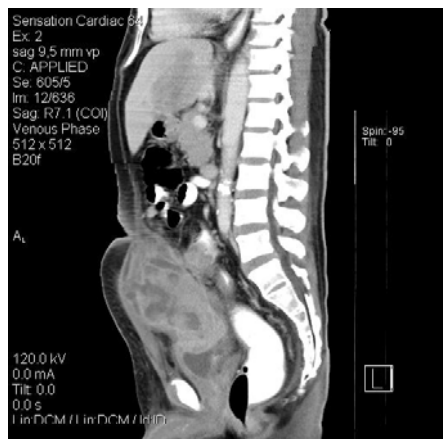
CT scan: intraabdominal mass infiltrating into the roof of the urinary bladder
